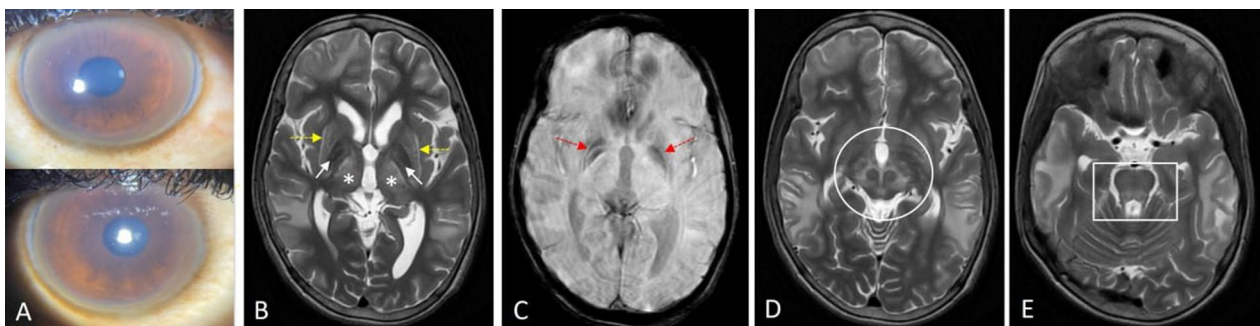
Slit lamp examination of both eyes showing bilateral Kayser-Fleisher rings (A). Axial T2 weighted MR image (B) shows symmetrical hyperintensity in bilateral caudate, putamen, posterior limb of internal capsule, bilateral thalami (white asterisks) and bright claustrum sign (yellow arrows). Symmetrical hypointensity is noted in bilateral globus pallidi (white arrows). Axial SWAN MR image (C) shows symmetrical areas of blooming in bilateral globus pallidi (red arrows). Axial T2 weighted MR image at the level of midbrain (D) and at the level of pons (E) shows “face of giant panda sign” (white circle) and “face of miniature panda sign” (white box) respectively
